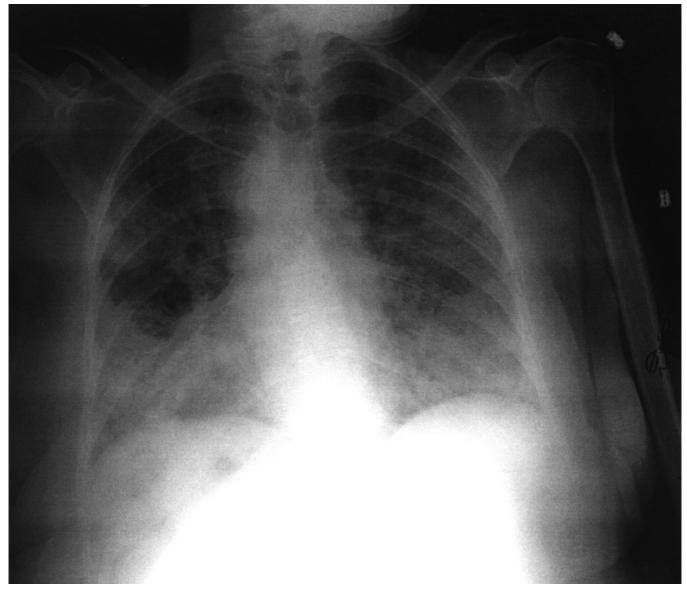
A 55 year old woman with advanced HIV infection presented with three weeks of dry cough, breathlessness, hypoxemia and fever. Her chest radiograph shows diffuse interstitial in Itrates. Induced sputum revealed *P. carinii*.
